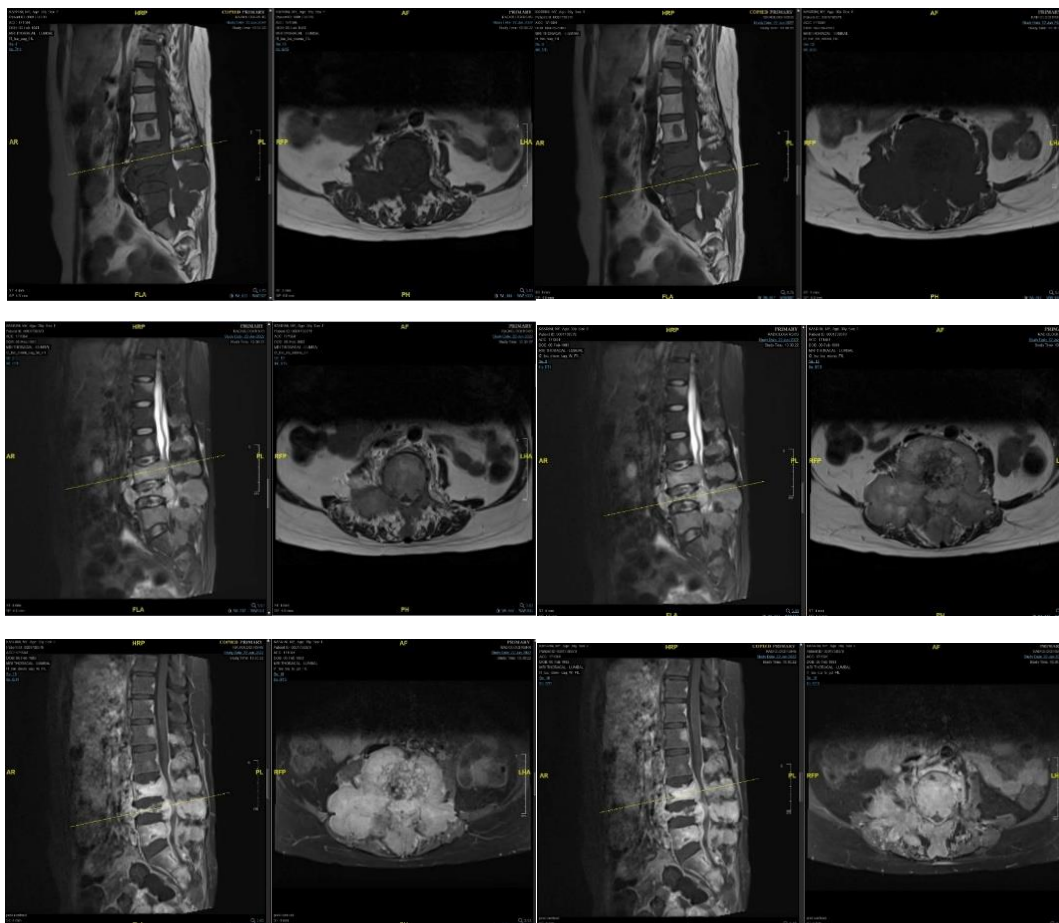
Contrast Lumbosacral MRI at Hasan Sadikin Hospital June 24th 2022.
